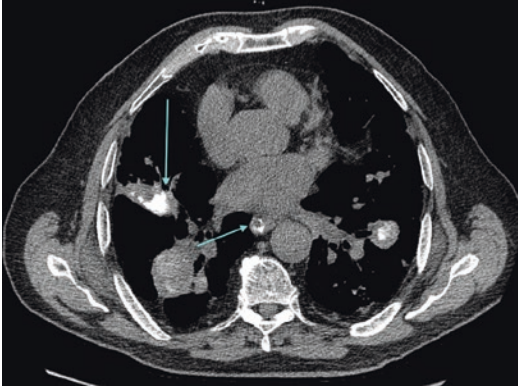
Eggshell calcifications. Simple silicosis in an 80-year-old man who worked for 20 years in a coal mine. Thin-section unenhanced CT scan (1.0 mm thick) in mediastinal window settings at the level of the bronchus intermedius shows eggshell calcifications (arrows) in a subcarinal lymph node
